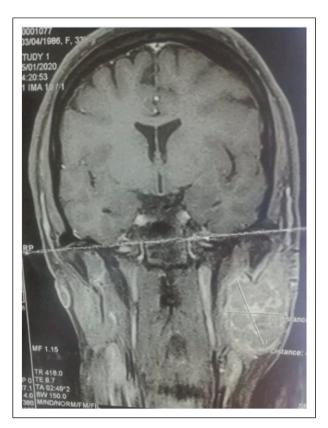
Cervical MRI showing the left parotid lesion in the form of a heterogeneous T2 hypersignal.
